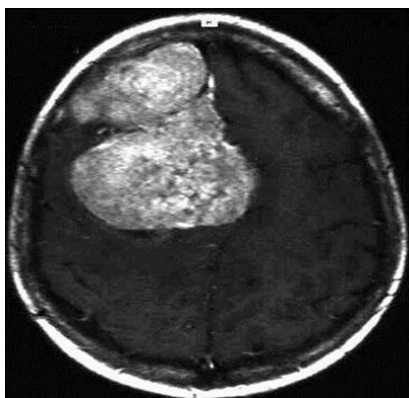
MRI image of meningioma reaching the Rolandic area
